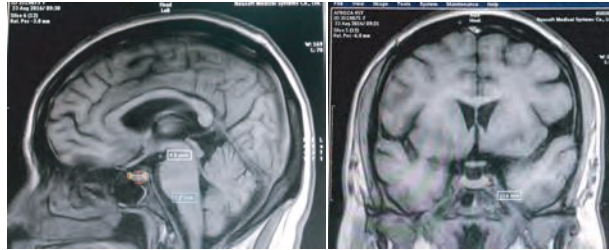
Sagittal & coronal T1-weighted MRI in 45year old female shows height, depth & width of pituitary gland.
